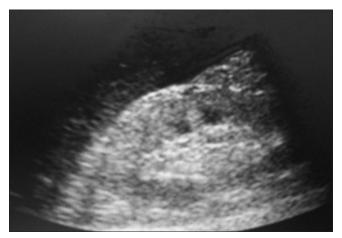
Longitudinal sonogram of the right kidney showing grade II renal echogenicity in a patient with HIVAN
